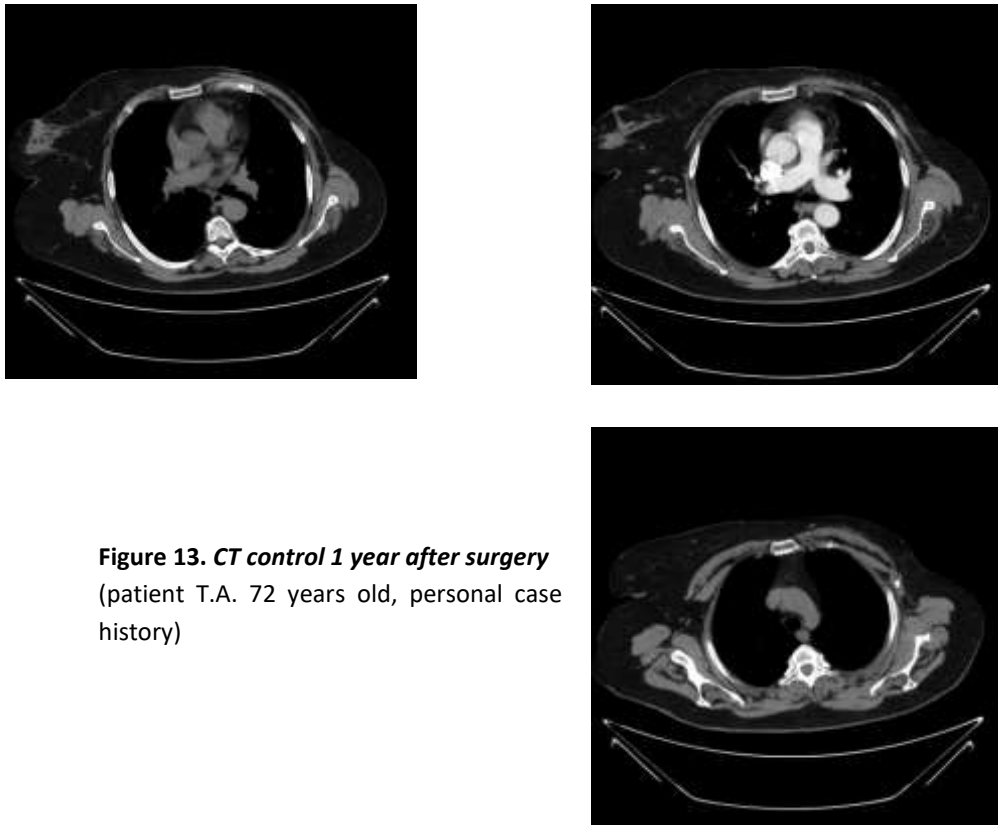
CT control 1 year after surgery
